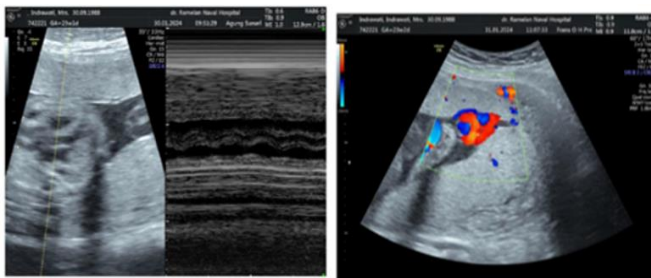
MCA-PSV Doppler ultrasonography obtained 1.6-1.8 MoM with Hydrops fetalis
